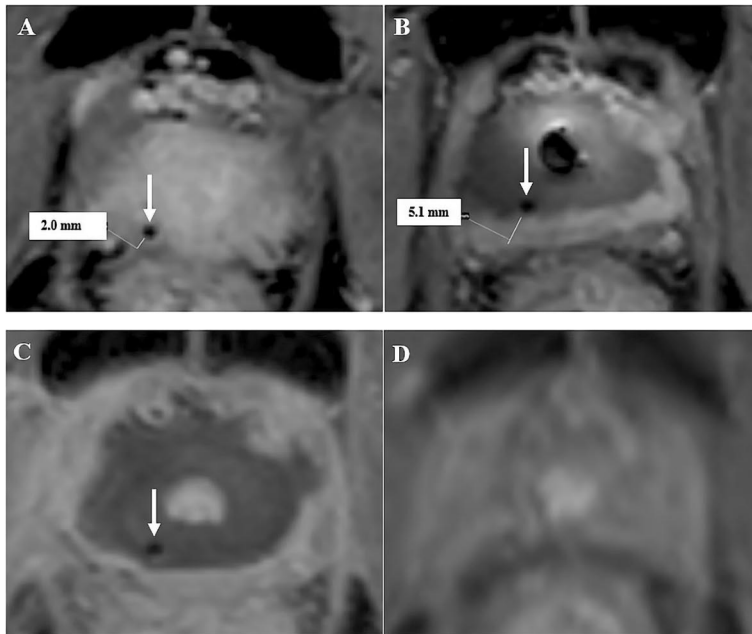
Example of a patient with a gold fiducial marker located on the right apical posterolateral corner (white arrow). The amount of enhancing tissue between marker and prostate capsule is shown (A) on baseline MRI scan and (B) immediately after treatment. At 3-month MRI (C), no enhancing prostatic tissue behind the marker was seen, only periprostatic enhancing fibrotic capsule. At 12-month MRI (D), both the non-perfused tissue and marker had disappeared. (From original publication II)
